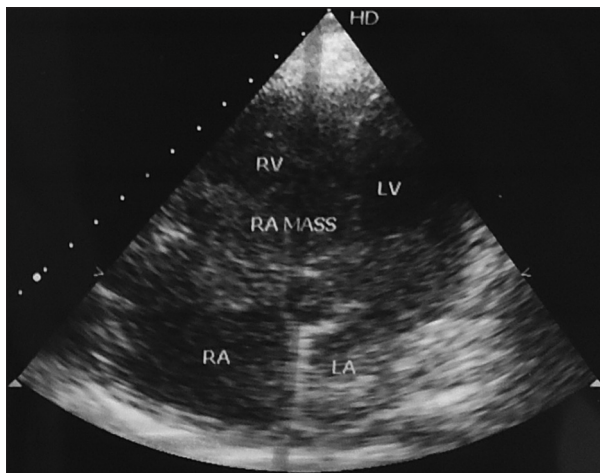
Right atrial myxoma seen in transesophageal echocardiography
